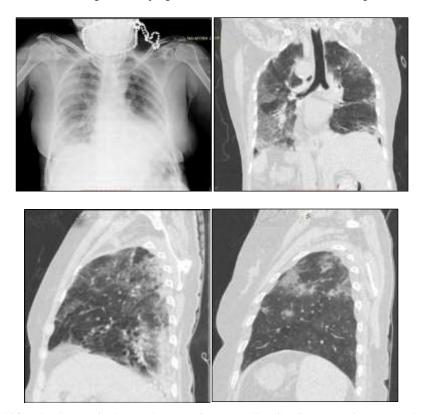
83 yr. old female, characterized as moderate on CXR as well as CT. CXR (AP-view); coronal, right sagittal and left sagittal HRCT (from top right then clockwise)
